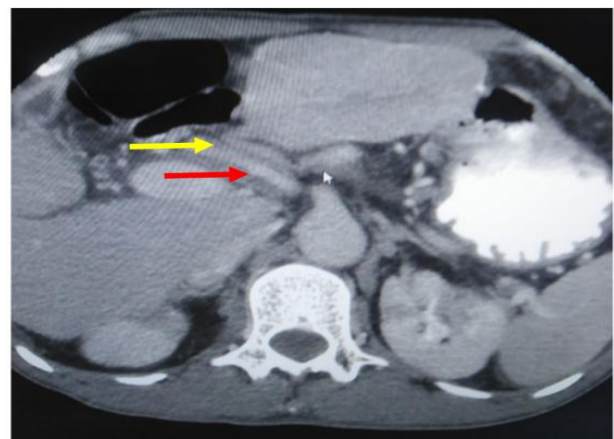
Abdominal CT scan with contrast revealing thrombosis (red arrow) lodged in superior mesenteric artery (yellow arrow).
